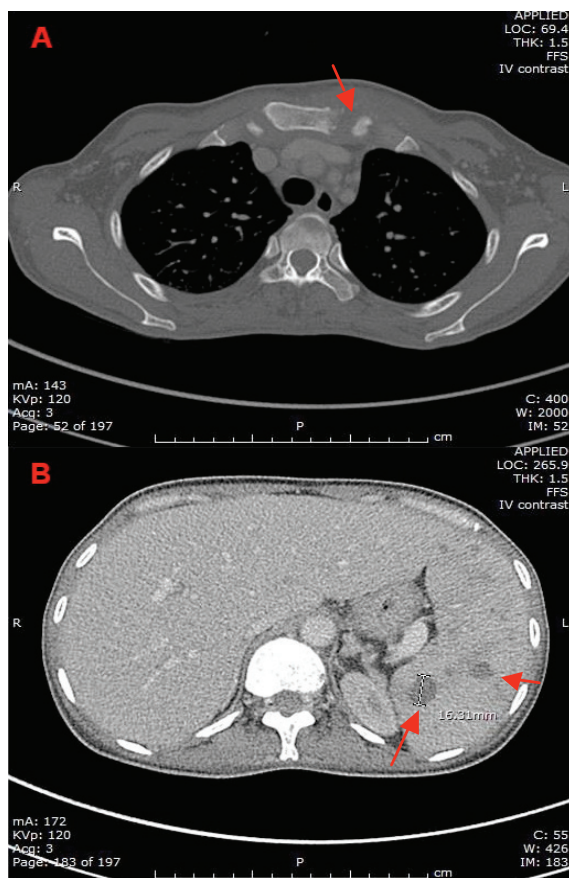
Computed tomography of chest (3A) and abdomen (3B) revealing a periarticular osteolytic lesion of the left SC joint (arrow), hepatosplenomegaly, and multiple, varying in size, hypodense splenic lesions (two arrows).
